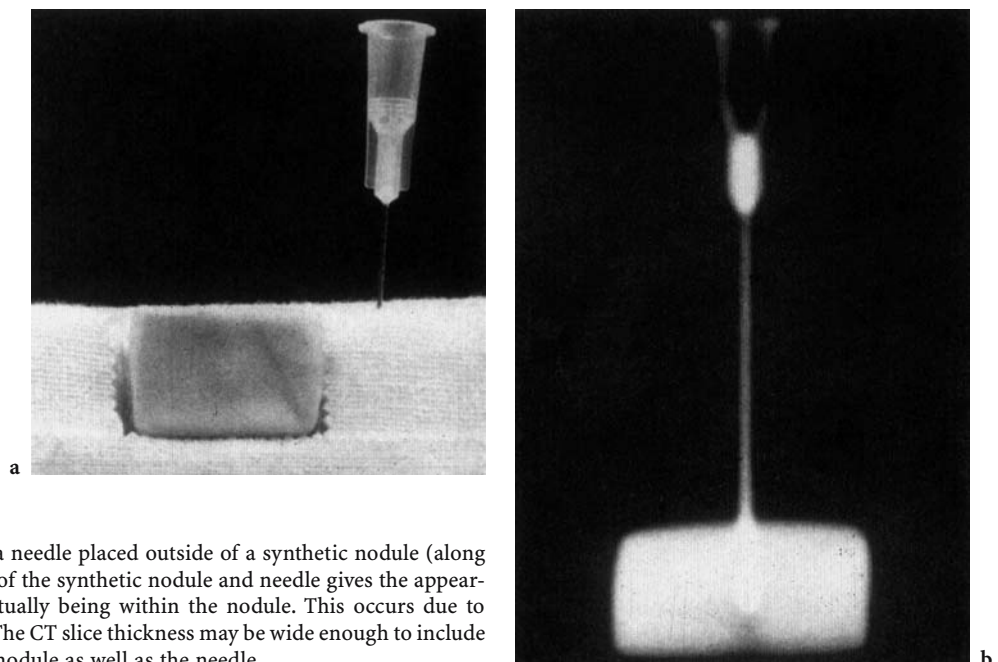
a Picture of a needle placed outside of a synthetic nodule (along the z-axis). b CT scan of the synthetic nodule and needle gives the appearance of the needle actually being within the nodule. This occurs due to partial volume effect. The CT slice thickness may be wide enough to include both a portion of the nodule as well as the needle
